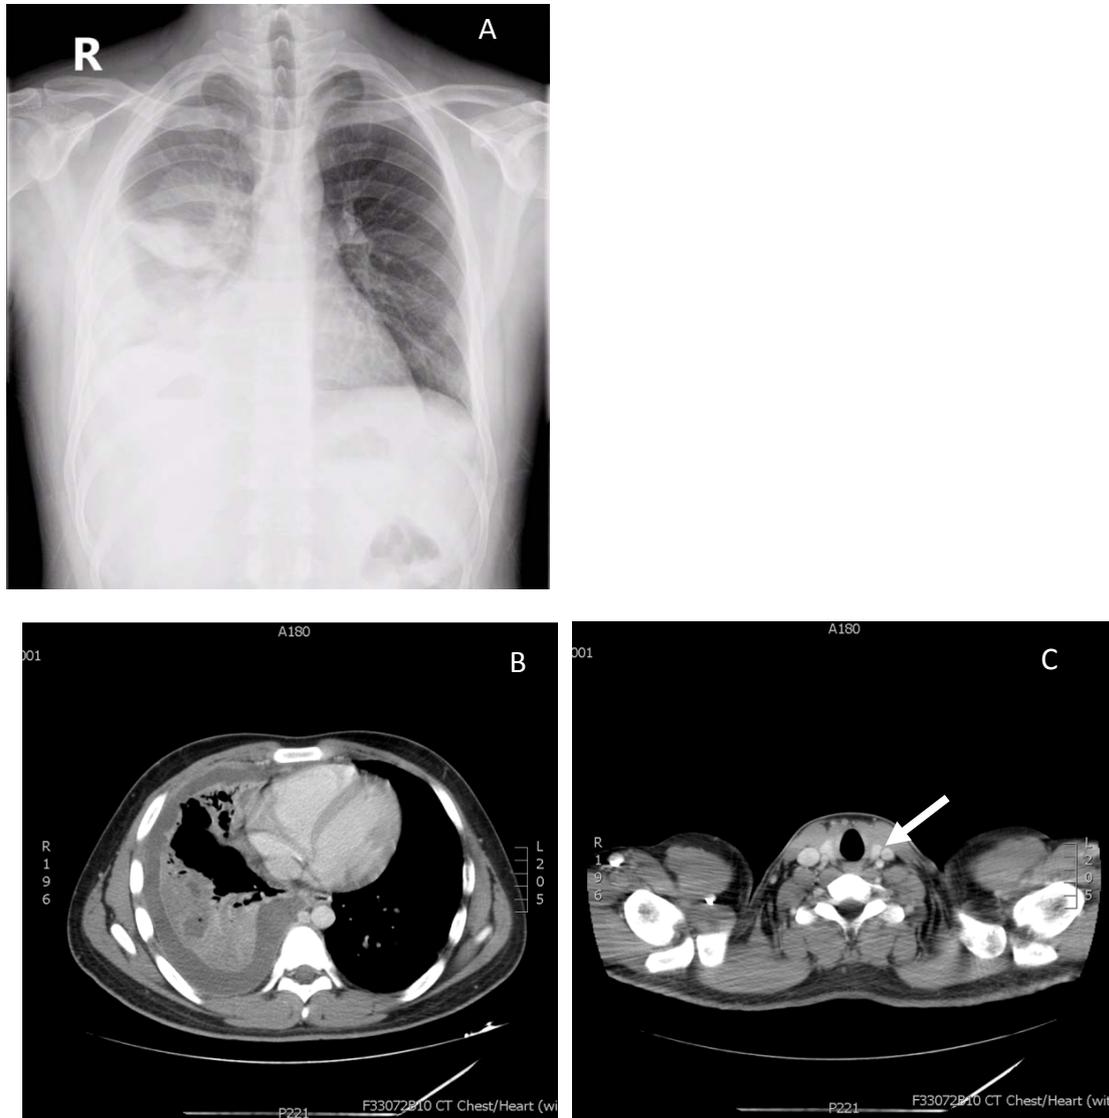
The chest x-ray and CT scan revealed infiltration and consolidation of right lower lobe of lung (Fig 1A and 1B). The Fig 1C showed left internal jugular vein thrombosis(white arrow site)
